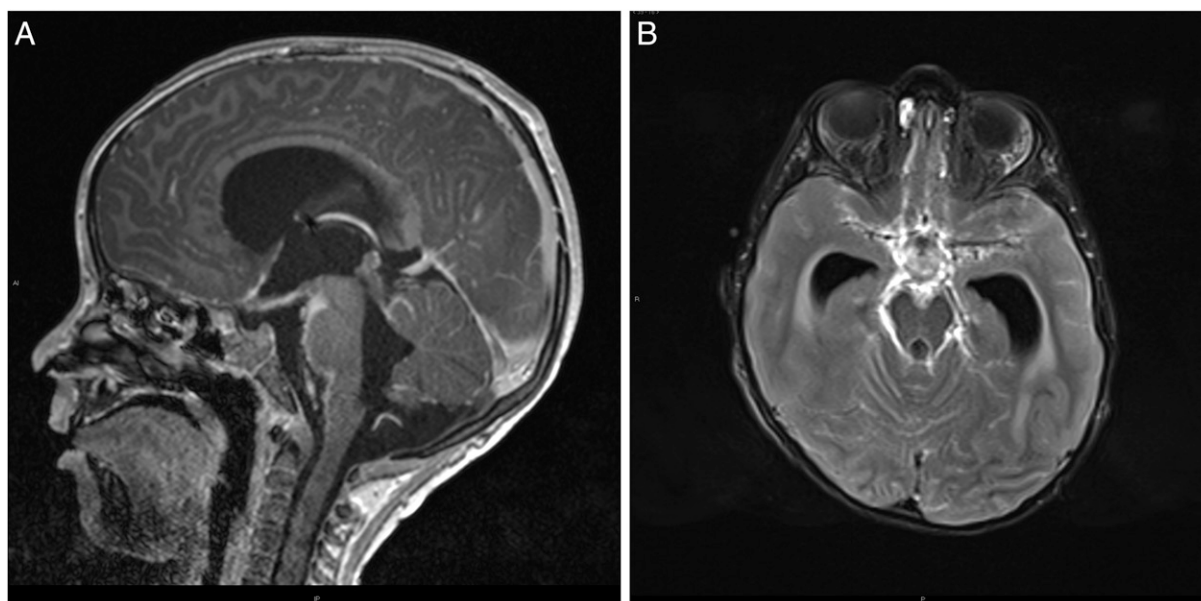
Magnetic resonance images of the patient's brain. A. Sagittal T1-weighted magnetization-prepared rapid gradient-echo postcontrast view demonstrating basal cistern and leptomeningeal enhancement. B. T2-weighted fluid-attenuated inversion recovery fat-saturated postcontrast view demonstrating leptomeningeal and cisternal enhancement involving the quadrigeminal and suprasellar cisterns.
